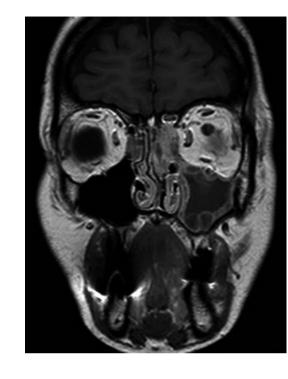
Coronal T1-weighted MRI with gadolinium showing *left* sinonasal lymphoma with extension into frontal sinus
